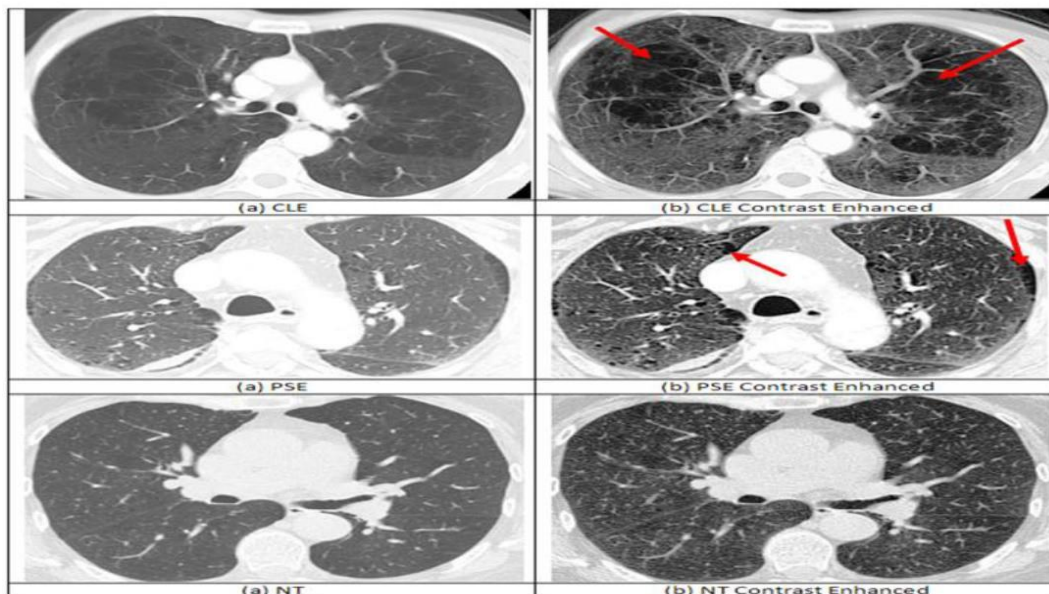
HRCT images showing emphysema disease patterns. The images in the first column were obtained from Radiopaedia [11].
